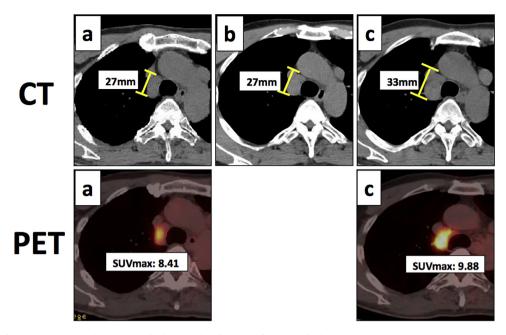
<sup>18</sup>F-fluorodeoxyglucose positron emission tomography (FDG-PET) and computed tomography (CT).
